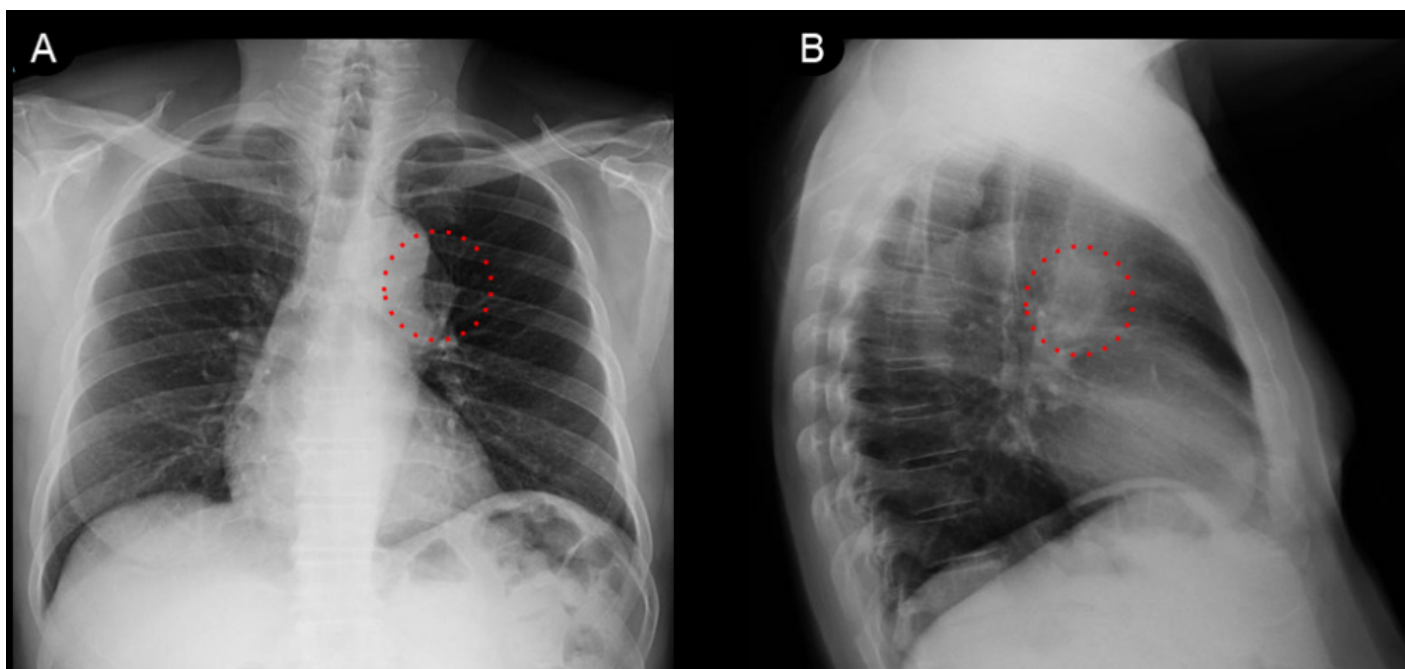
The anteroposterior (A) and lateral (B) views of the chest radiograph demonstrate a bulging in the subaortic space (aortopulmonary window) (red arrowhead).
